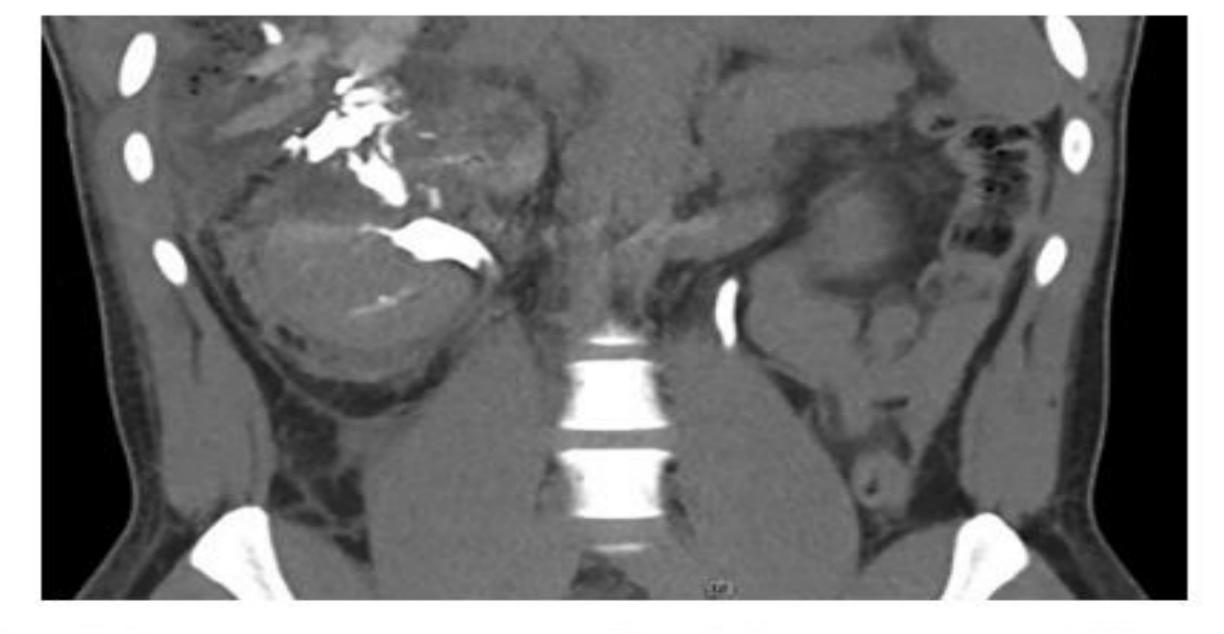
In the same patient as Fig. 94.5, delayed phase CT scan, demonstrates urinary extravasation.
